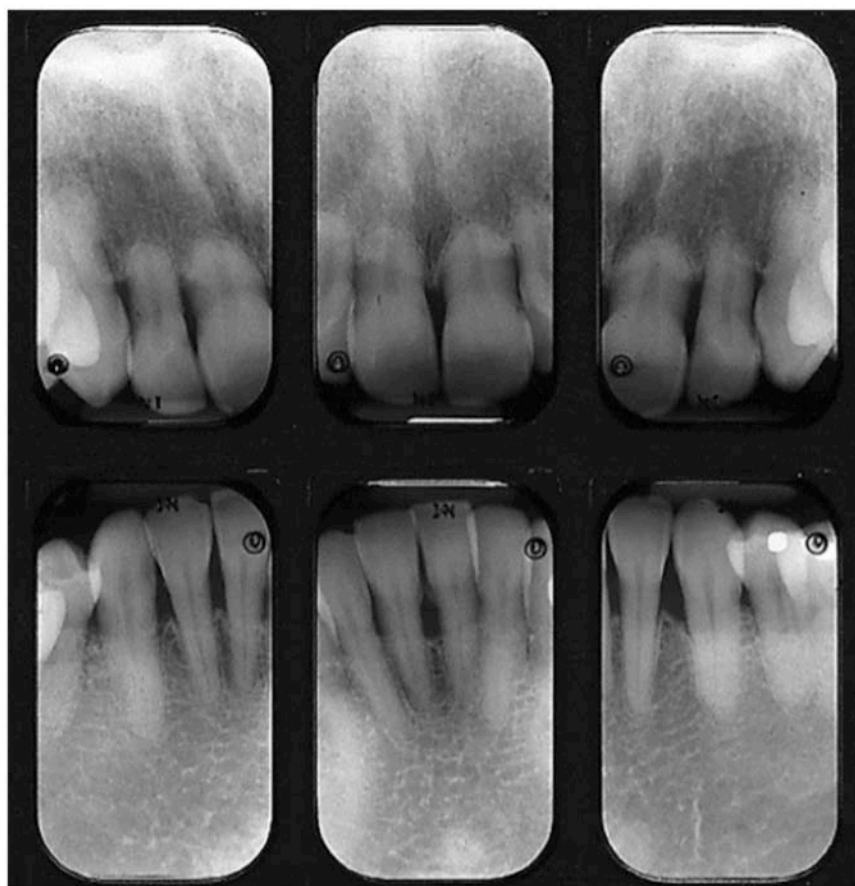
Anterior periapical radiographs of teeth with external resorption, especially severe on the maxilla.
